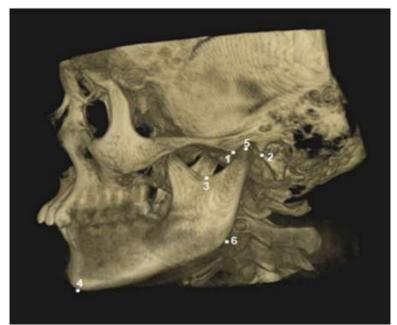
(c):- Anatomic Landmarks used in CBCT study.
